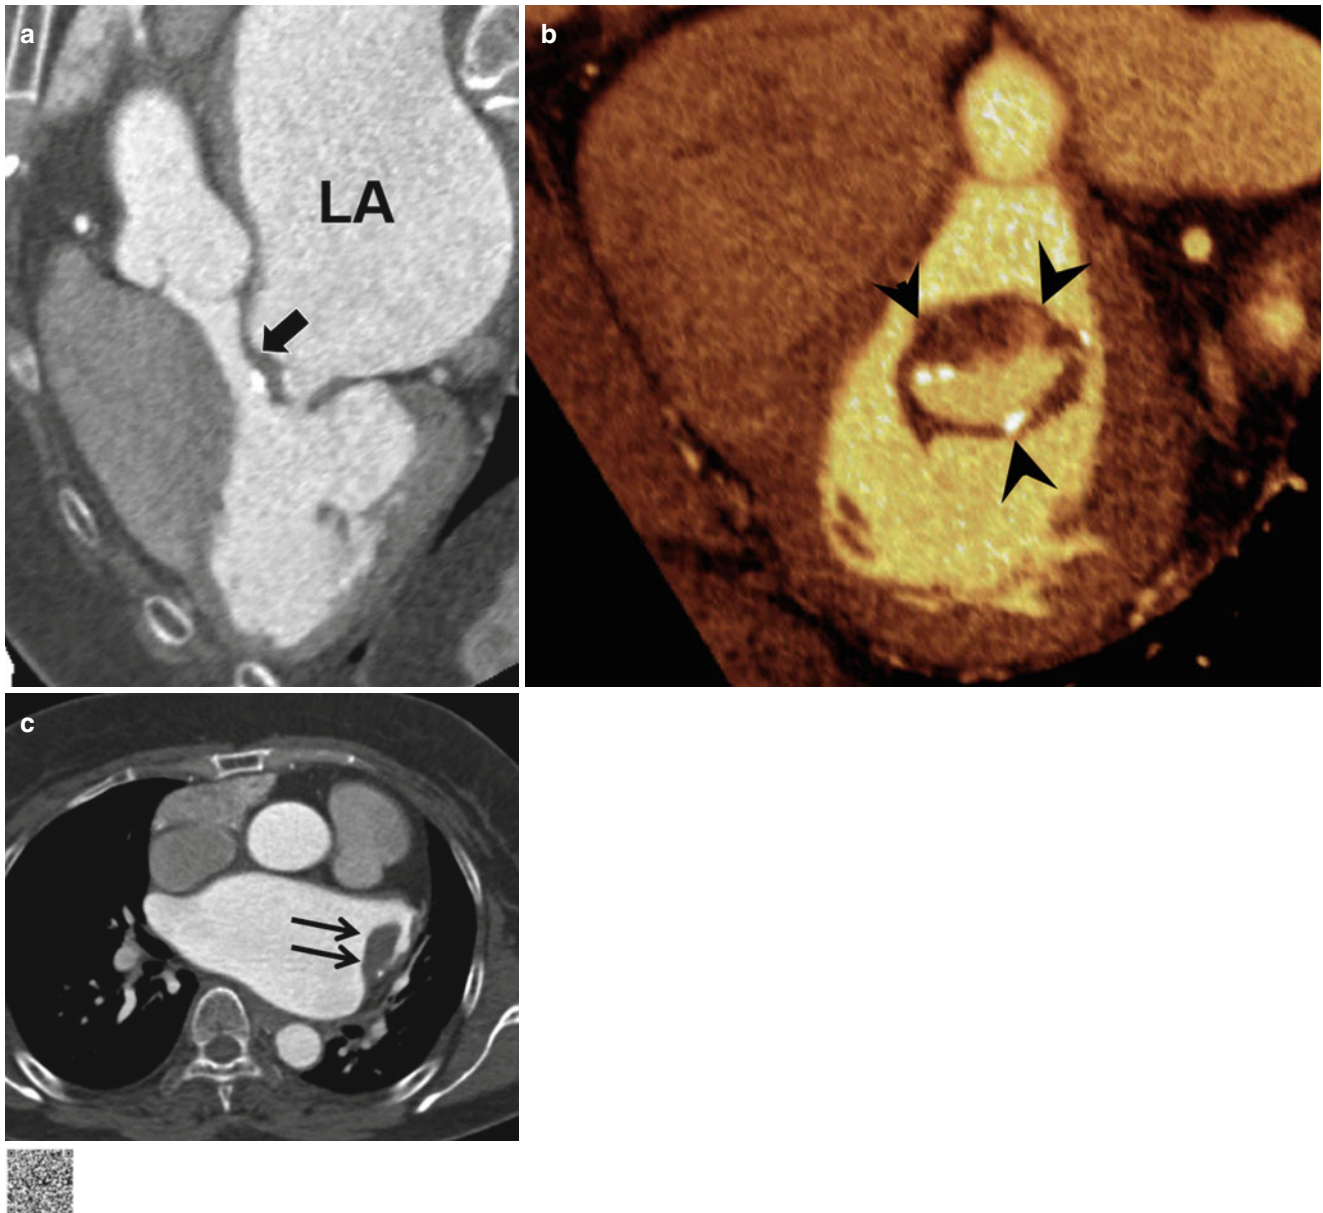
Typical finding of mitral stenosis with left atrial thrombus (<http://extras.springer.com/2015/978-3-642-36396-2>). (a) Three-chamber view of CT shows thickening and doming of the mitral valve (MV) in diastolic phase. Note a “hockey stick” appearance (*arrow*) of the MV anterior leaflet due to motion limitation. The left atrium (LA) shows severe
